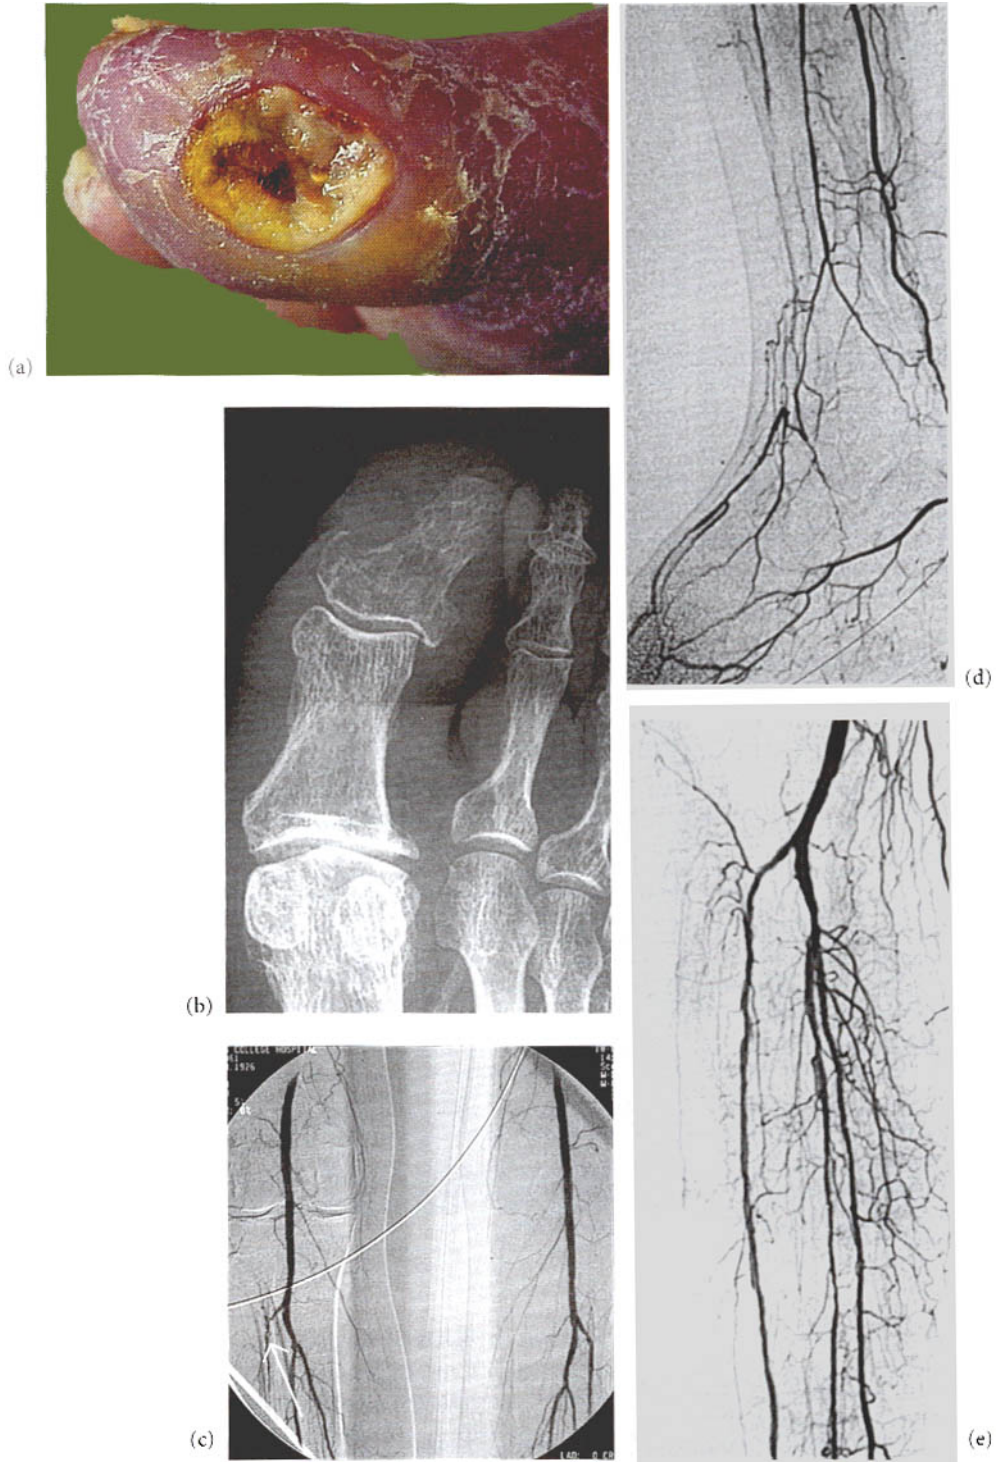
(a) Ulcer with cellulitis on toe spreading to the foot. (b) X-ray was initially normal. (c) Stenosis at origin of anterior
